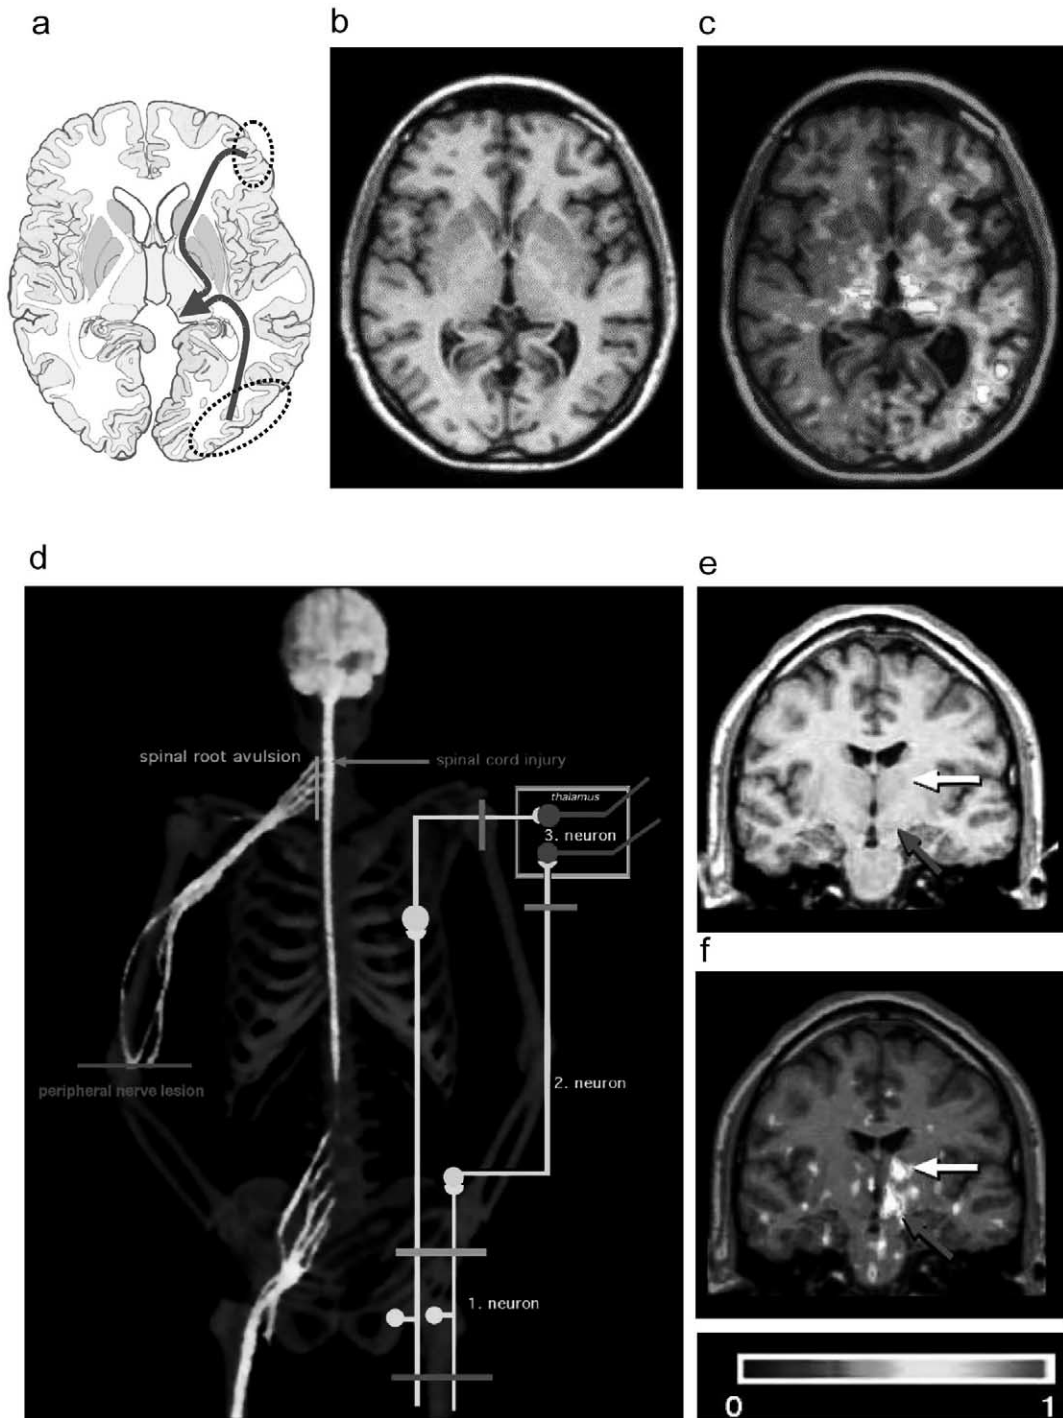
(a–b) Subacute neuroinflammatory signals, as measured (c) by  $[^{11}\text{C}](R)\text{-PK11195}$  PET and superimposed on a (b) structural magnetic resonance image, are seen in this patient approximately 2 weeks after a cerebral stroke, having affected the cortex in one hemisphere. Increased signal is not only seen in the lesioned cortex, but also in the ipsilateral thalamus as a consequence of injury to the corticothalamic connections. (d–f) Peripheral nerve lesion (d), such as through limb amputation, injures the 1. neuron and (e, f) leads to a contralateral  $[^{11}\text{C}](R)\text{-PK11195}$  PET signal in the thalamus (white arrow), indicating a spread of the glial responses to structurally unaffected transsynaptic projection areas (dark arrow = area of the red nucleus).
